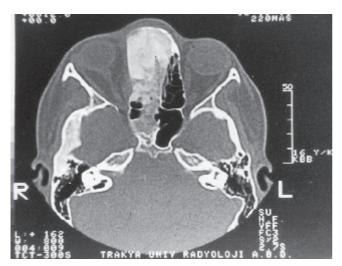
Axial CT scan revealing FD of the right ethmoid and sphenoid sinuses, and the right temporal bone.
